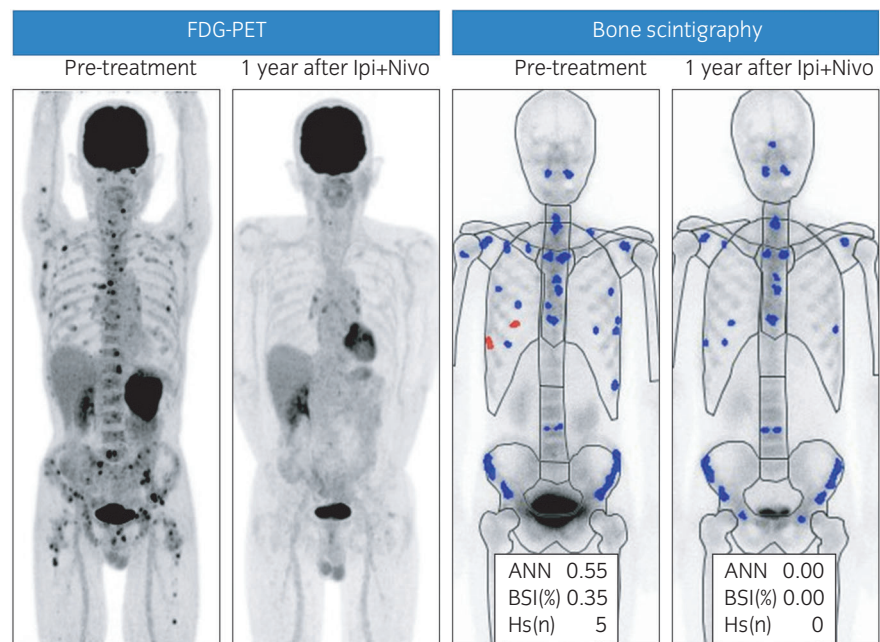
FDG-PET CT and bone scintigraphy findings before cytoreductive nephrectomy and 1 year after ipilimumab plus nivolumab therapy, showing the complete remissions of multiple osseous metastases.
